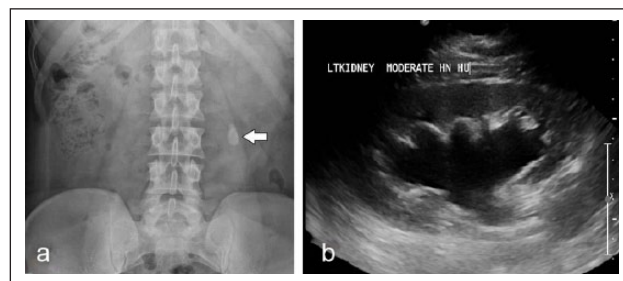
(a) KUB X-ray shows left upper ureteric calculus at the level of L4. (b) Renal ultrasound shows moderate dilatation of pelvicalyceal system of the same patient.
